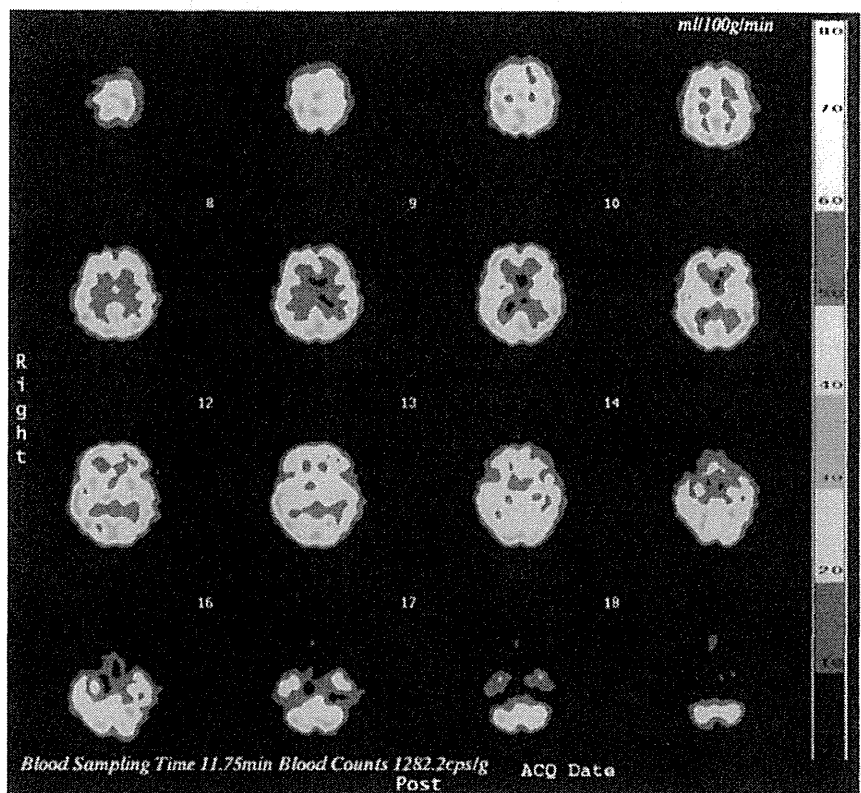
N-isopropyl-[123I]p-iodoamphetamine single photon emission computed tomography showed hypoperfusion in the whole brain, which was predominant in the left frontal lobe.
